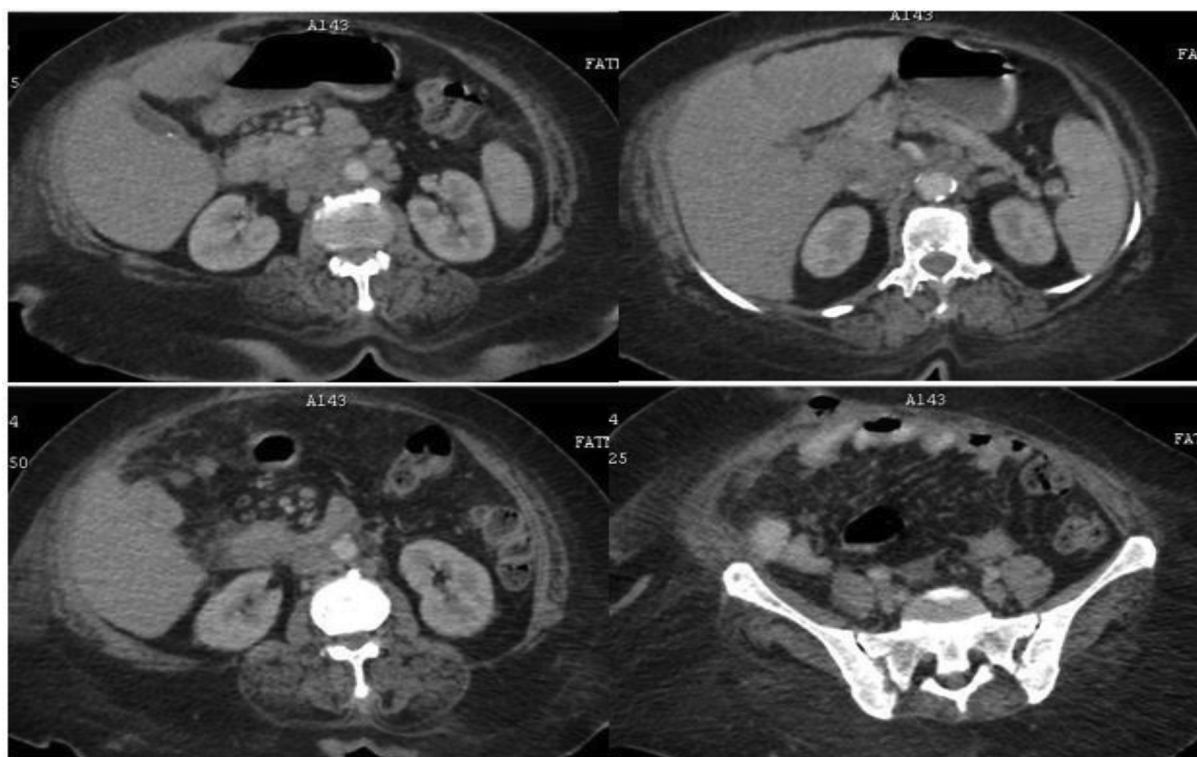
A 46-year-old woman with cancer colon with suspected peritoneal carcinomatosis. Axial arterial phase. CT images revealed multifocal discrete nodules in the peritoneal cavity with peritoneal thickening and dirty fat planes.
